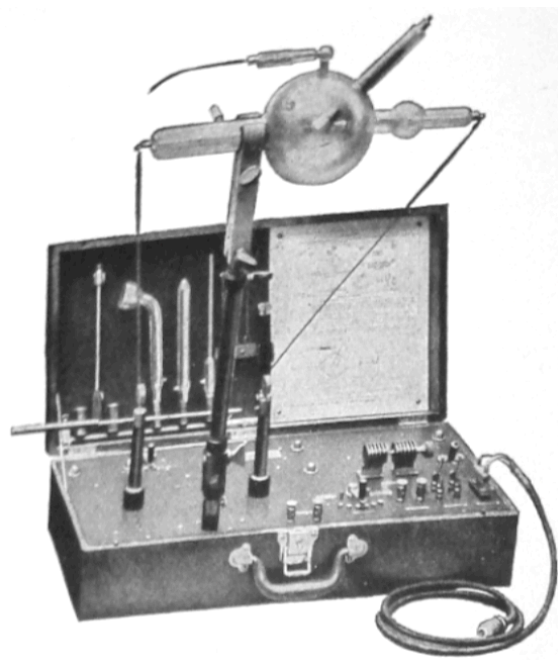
McIntosh Radiographic Suit Case Portable Coil.²⁶⁴
